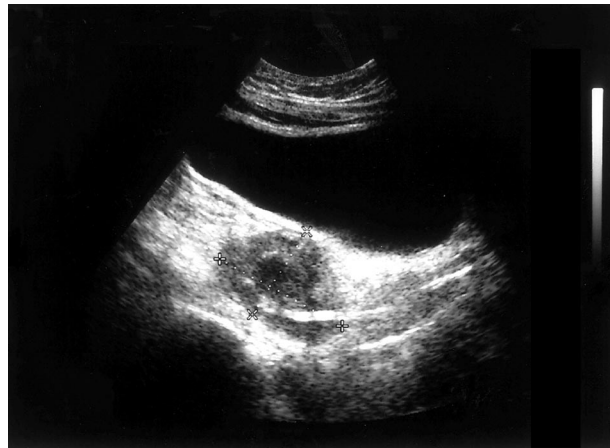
Ultrasound image of left adnexal mass 3 days after placement of transvaginal drain. The drain is seen as a hyperechoic line in the bottom half of the abscess.
